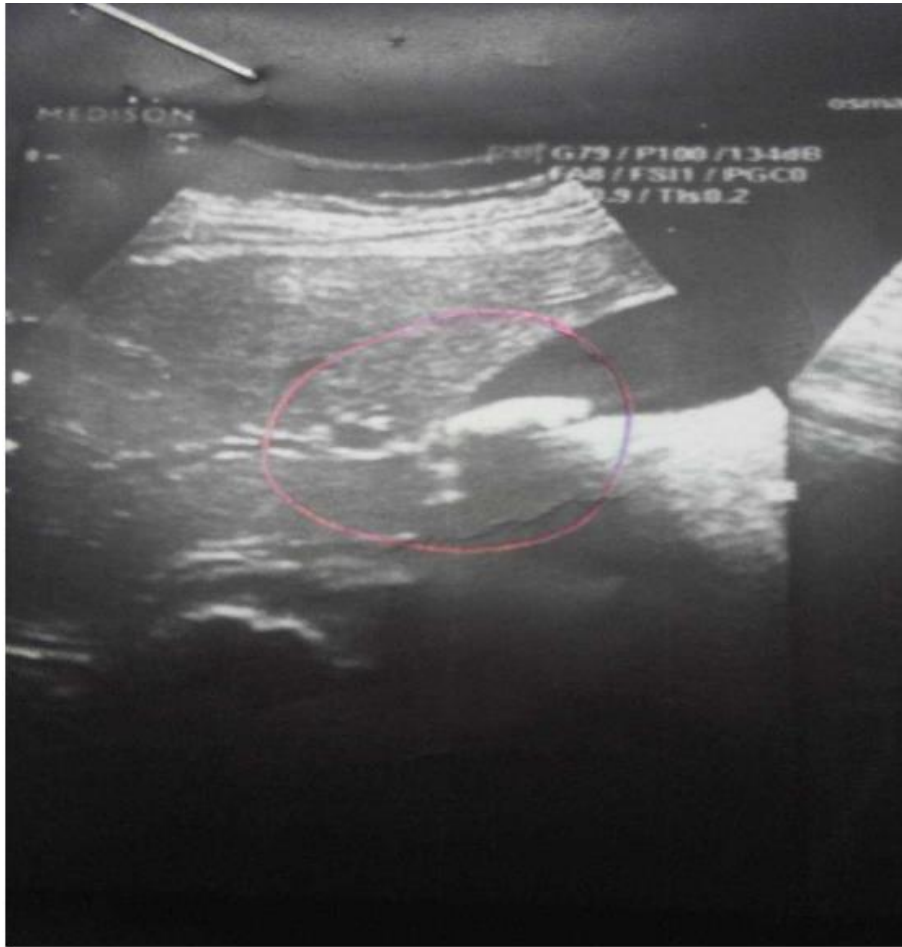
Ultrasound image shows stone with cystic duct.
